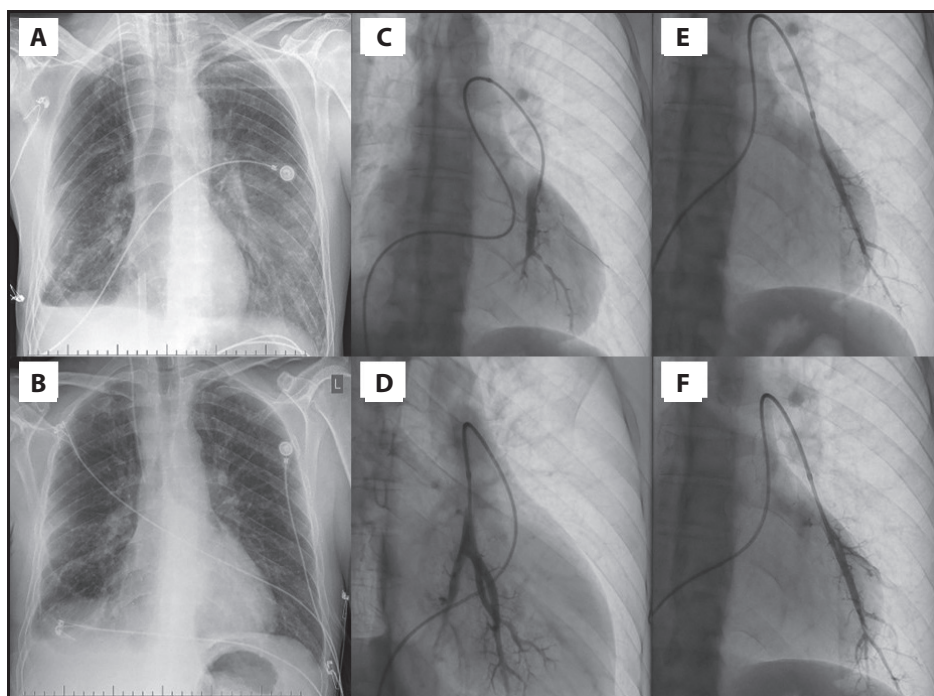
Chest X-ray displaying bilateral interstitial opacities taken the day after the BPA procedure (A) and after a week of therapy for reperfusion pulmonary edema (B). Pulmonary angiogram displaying the pulmonary artery to segments A9 and A10 before (C) and after (D) the BPA procedure, and the pulmonary artery to segment A8 before (E) and after (F) the BPA procedure
